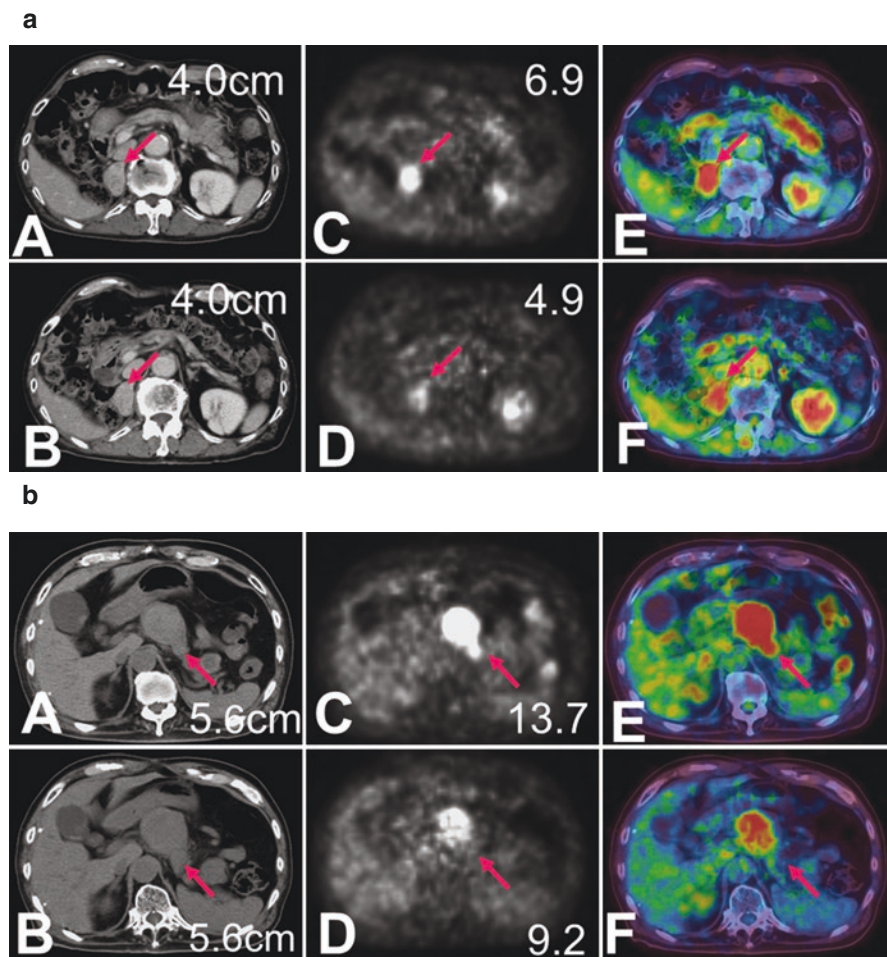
Early assessment by FDG PET/CT of patients with advanced RCC treated with mTOR inhibitor and progression-free survival. (a) A patient with adrenal metastasis. The max SUVmax before treatment and 1 month after mTOR inhibitor started were 6.9 and 4.9, respectively. His progression-free survival was 24.6 months. Upper lane: assessment before treatment. Lower lane: assessment at 1 month after VEGFr-TKI treatment started. (A, B) CT images (C, D) PET images (E, F) fusion images [31]. (b) A patient with pancreas metastasis. The max SUVmax before treatment and 1 month after mTOR inhibitor started were 13.7 and 9.2, respectively. His progression-free survival was 5.0 months. Upper lane: assessment before treatment. Lower lane: assessment at 1 month after VEGFr-TKI treatment started. (A, B) CT images (C, D) PET images (E, F) fusion images [31]
